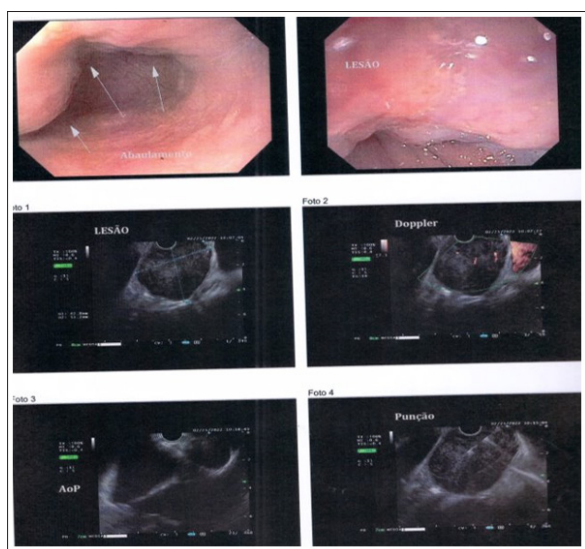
Upper digestive endoscopy image showing bulging mucous due to submucosal growth. At ultrasound (images below), evidence of submucosal expansive lesion
